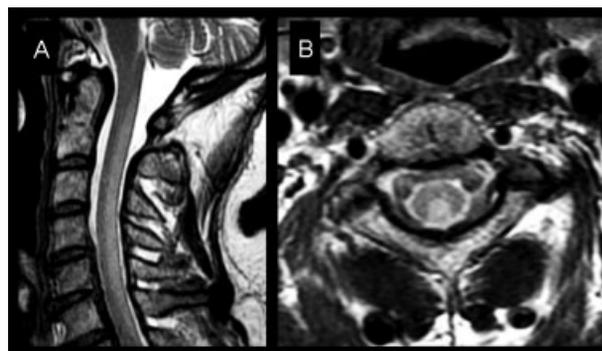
Vitamin B₁₂ deficiency. A woman presents with tingling and cramping sensations in both arms and legs, and low serum B₁₂. Sagittal (A) and axial (B) T₂-weighted magnetic resonance images show well-defined, confluent T₂-signal abnormality in the dorsal cervical cord without cord expansion.
